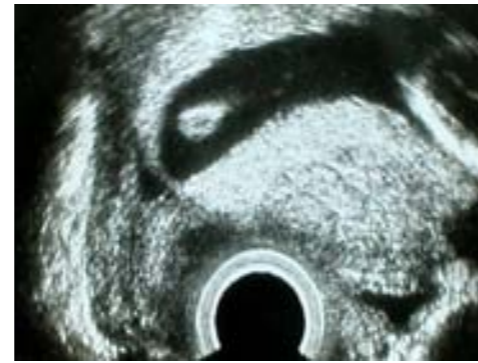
Transvaginal ultrasound showing complete placenta previa
